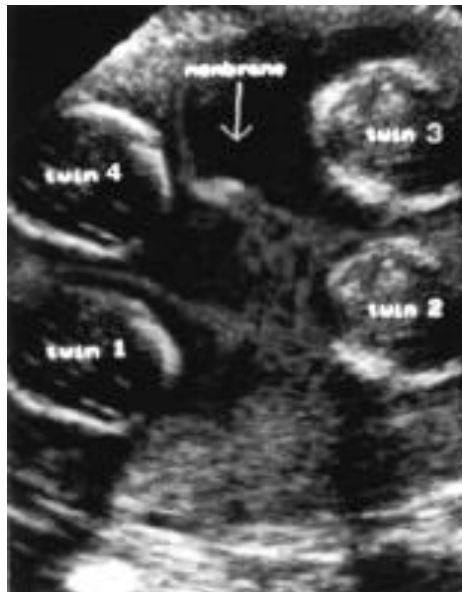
Ultrasound of quadruplet pregnancy showing membranes.
